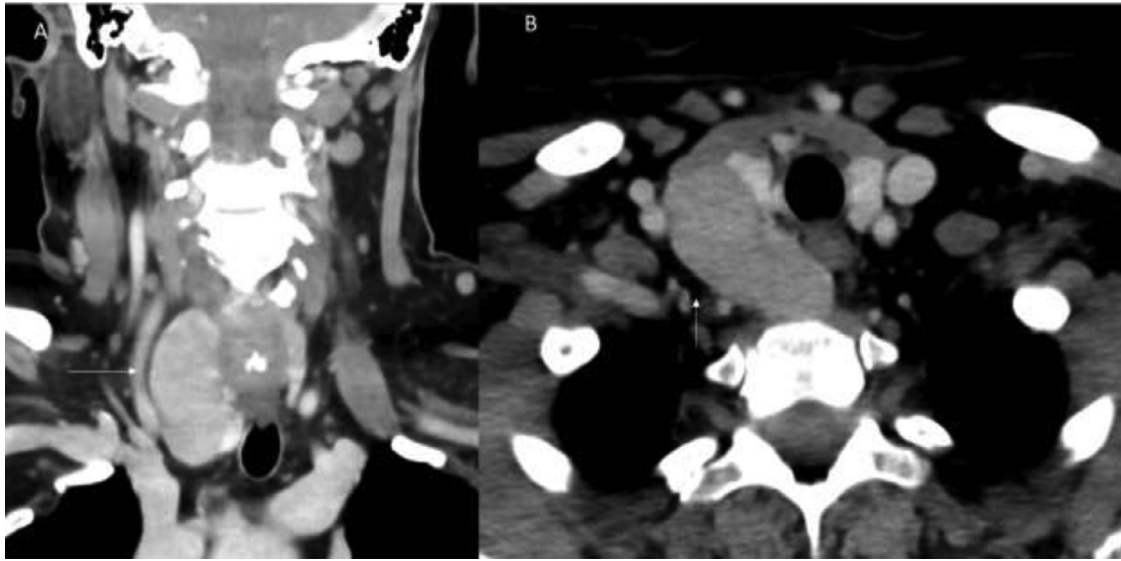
Coronal (A) and axial (B) contrast-enhanced CT neck images depicts the well-circumscribed homogenous mass (arrows) in the right thyroid region displacing the gland medially, extending into the mediastinum.
